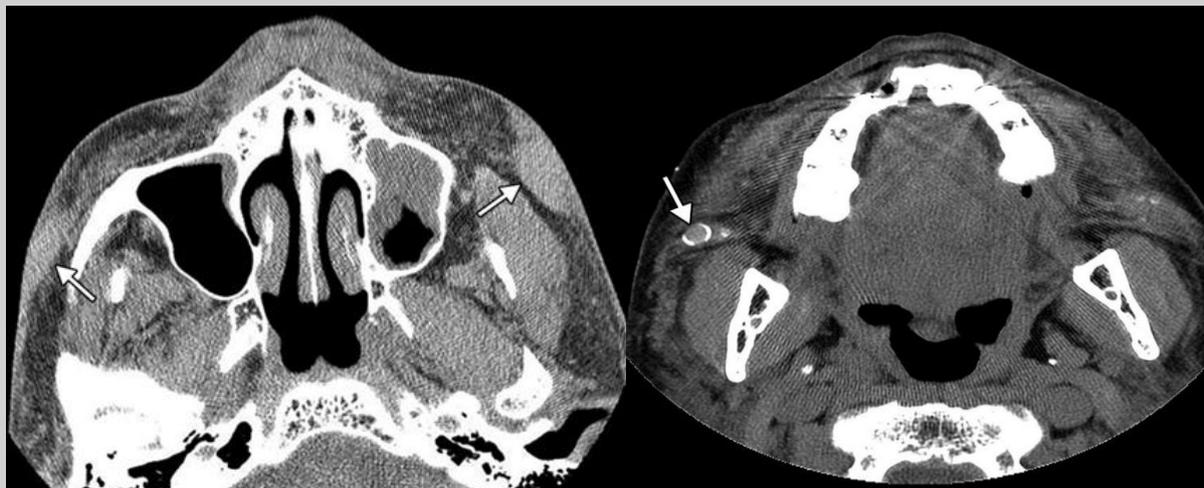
Axial CT image shows fibrotic bands within the subcutaneous tissues of both cheeks (arrows). Another axial CT image demonstrates a nodule with an eggshell calcification in the right cheek (arrow).
